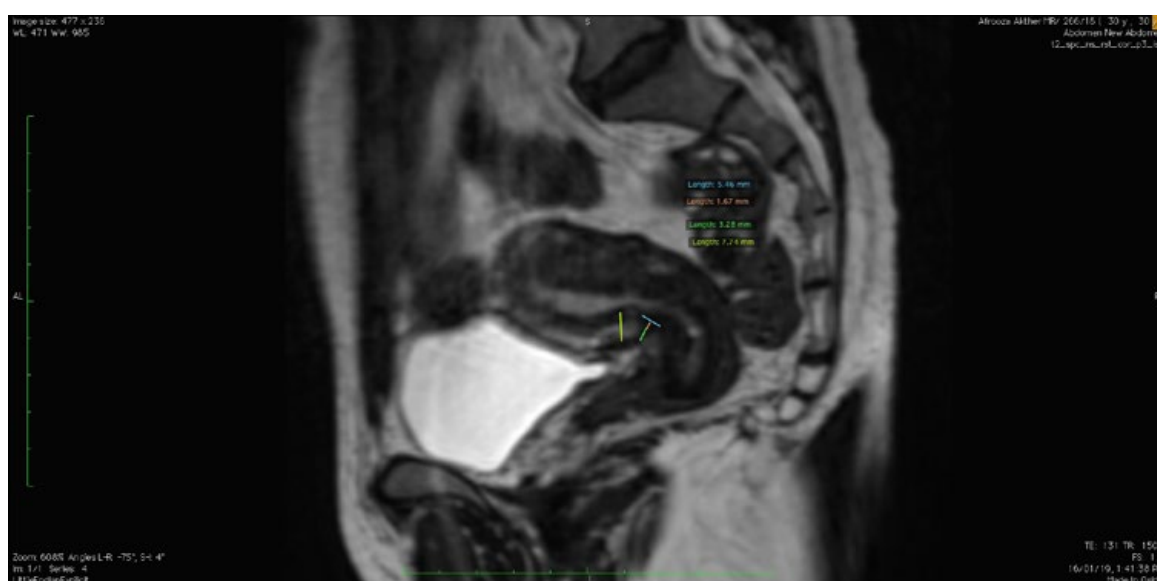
Sagittal T2-weighted MRI image depicting the uterus with callipers marking the 'niche' and its measurements.
